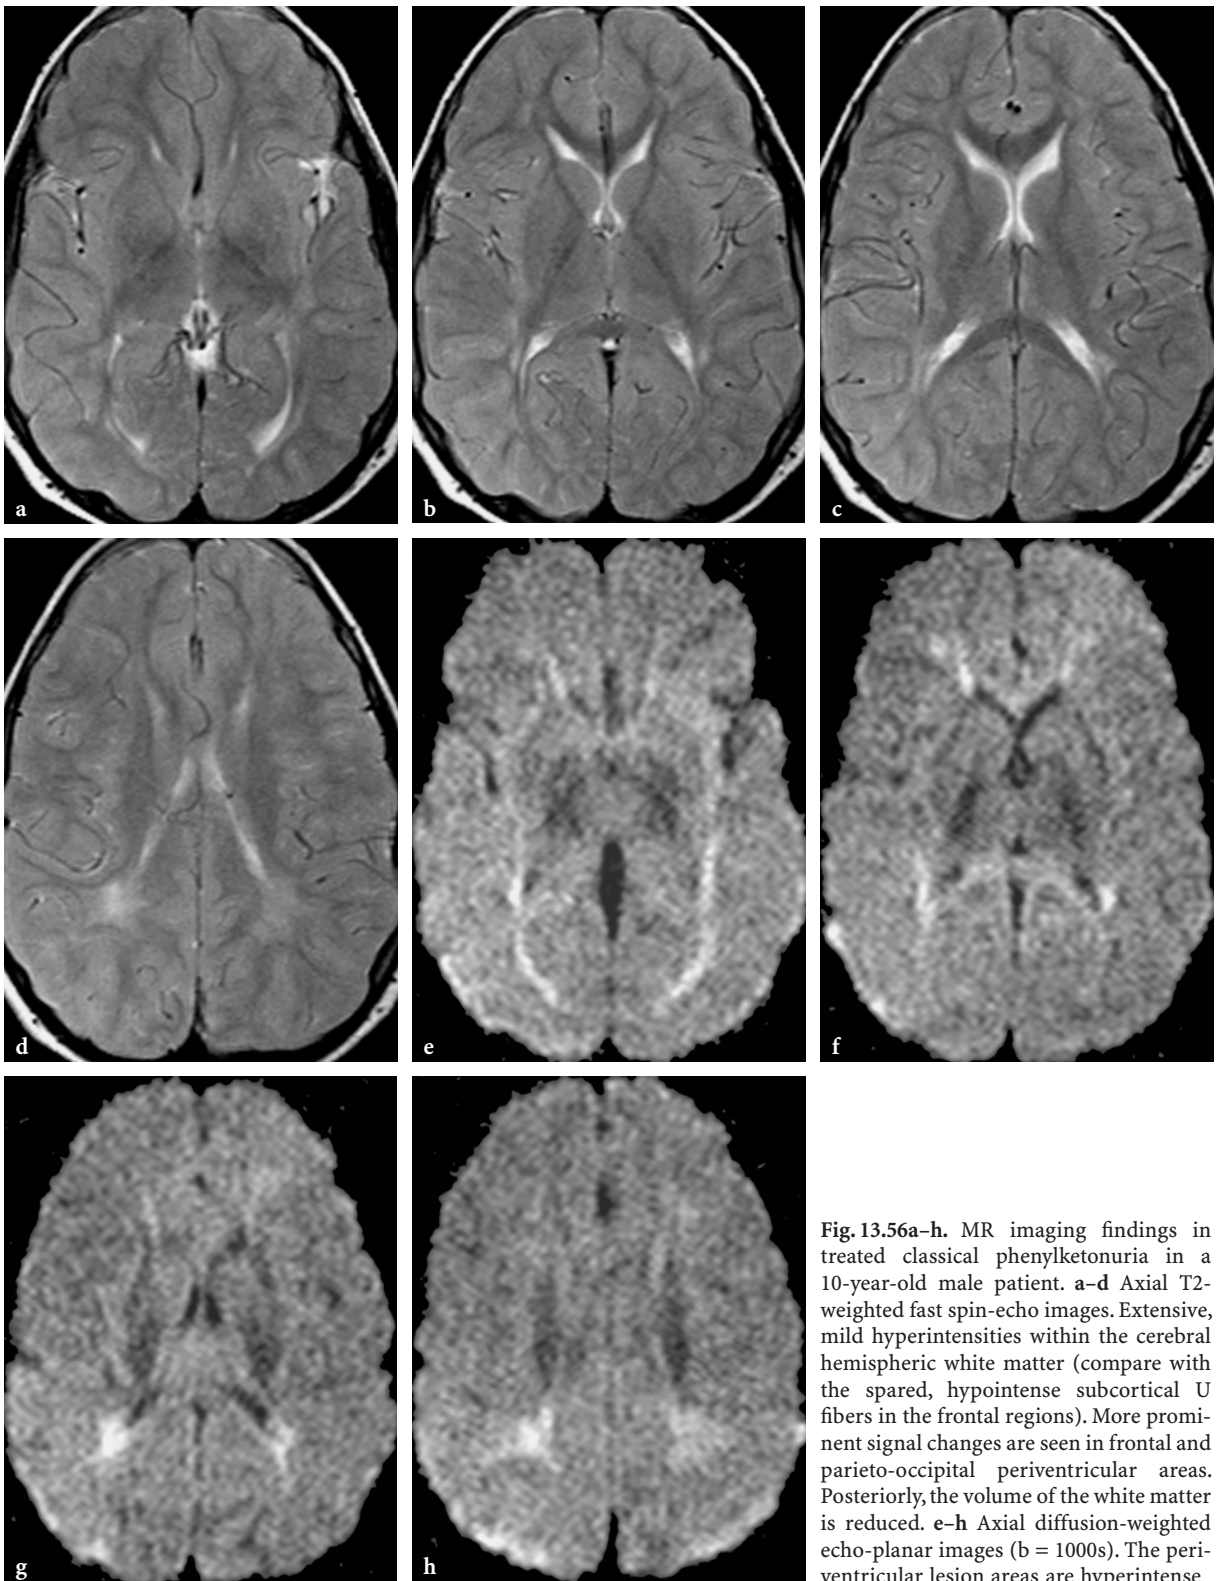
MR imaging findings in treated classical phenylketonuria in a 10-year-old male patient. a-d Axial T2-weighted fast spin-echo images. Extensive, mild hyperintensities within the cerebral hemispheric white matter (compare with the spared, hypointense subcortical U fibers in the frontal regions). More prominent signal changes are seen in frontal and parieto-occipital periventricular areas. Posteriorly, the volume of the white matter is reduced. e-h Axial diffusion-weighted echo-planar images ($b = 1000s$). The periventricular lesion areas are hyperintense
